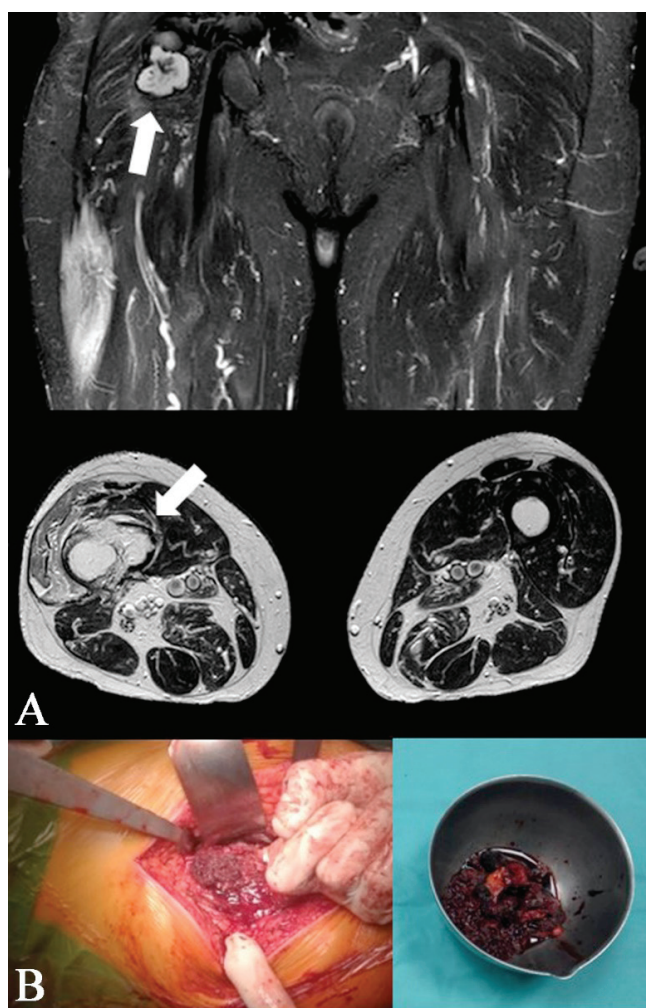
Pseudotumor of the right hip after MoM THA. MARS-MRI with pseudotumor (arrows) (A). Intraoperative views with metallosis (B).
